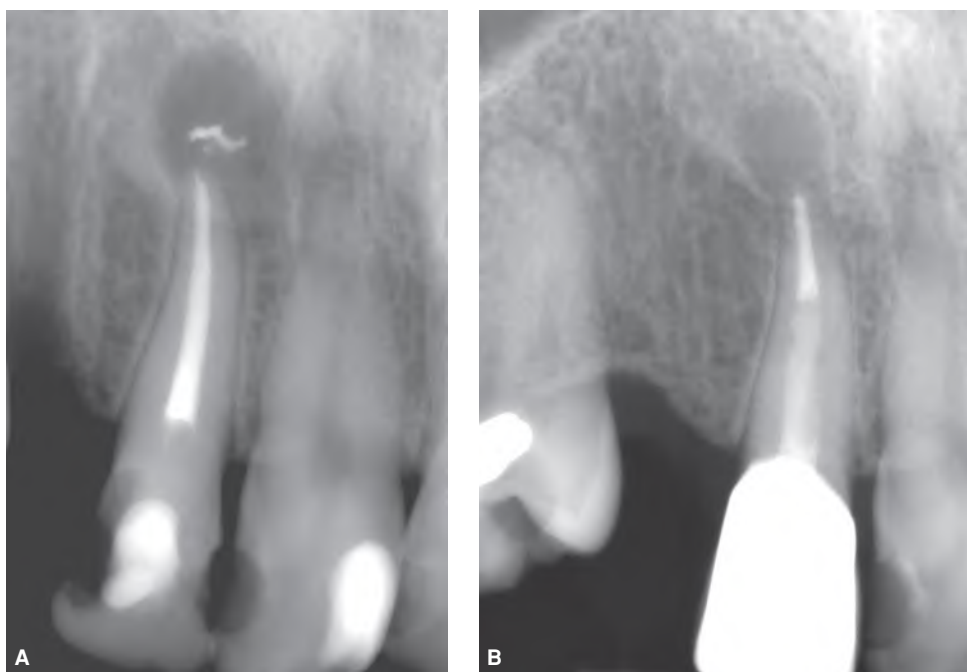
Lateral incisor with necrotic pulp and a large radiolucency. A. Post-obturation radiograph. B. Five-year recall. The lesion has slightly decreased in size. However, the residual radiolucency after a long observation period indicates root canal treatment failure.
